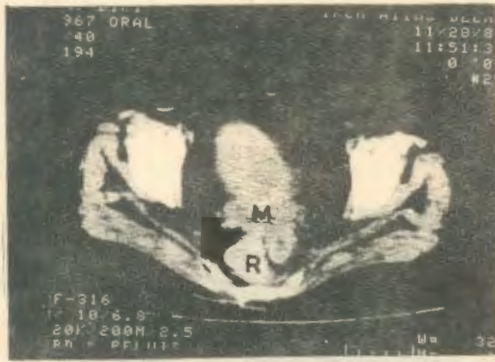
CT Scan of pelvis showing a large soft tissue mass (M) arising from the cervix and invading anterior rectal wall (R) as well as indenting the bladder.
